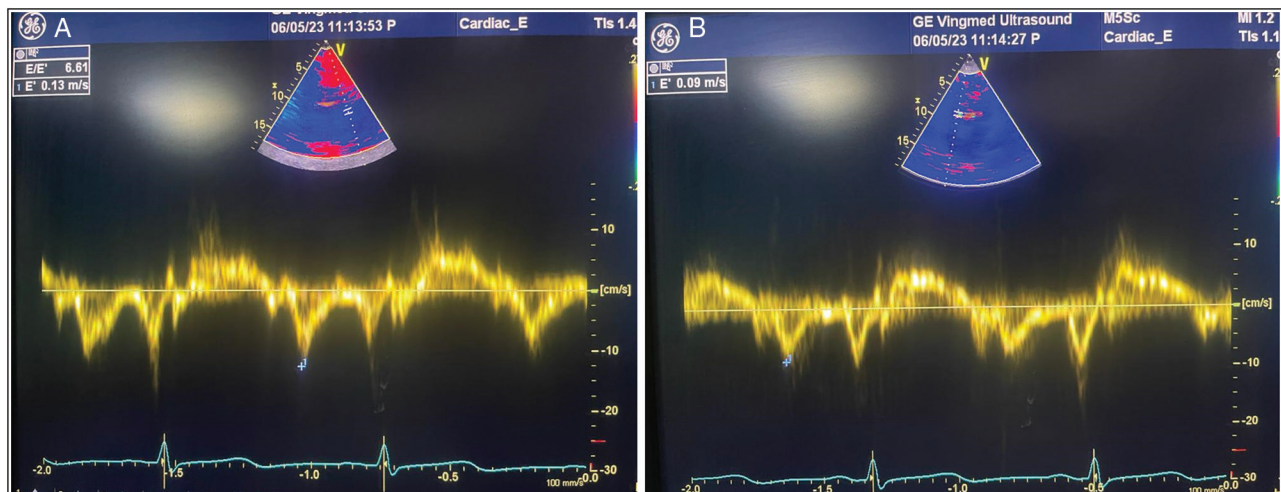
Pulsed tissue Doppler imaging (A) at the lateral and (B) at the septal mitral annulus demonstrate *e'* and *a'* waves
